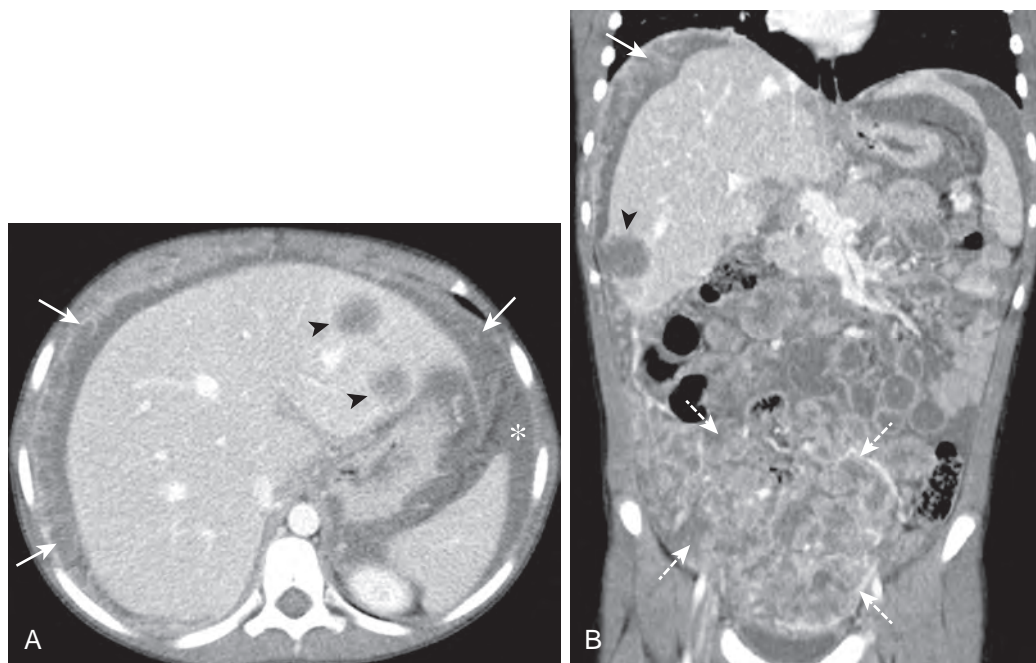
Desmoplastic small round cell tumor. An 8-year-old girl with desmoplastic small round cell tumor of the abdomen. Contrast-enhanced CT of the abdomen and pelvis. A. Axial image shows multiple peritoneal implants (arrows), complex ascites (asterisk), and hepatic metastases (arrowheads). B. Coronal image shows a large mesenteric mass (dashed arrows) in addition to the peritoneal implants (solid arrow) and hepatic metastasis (arrowhead).
